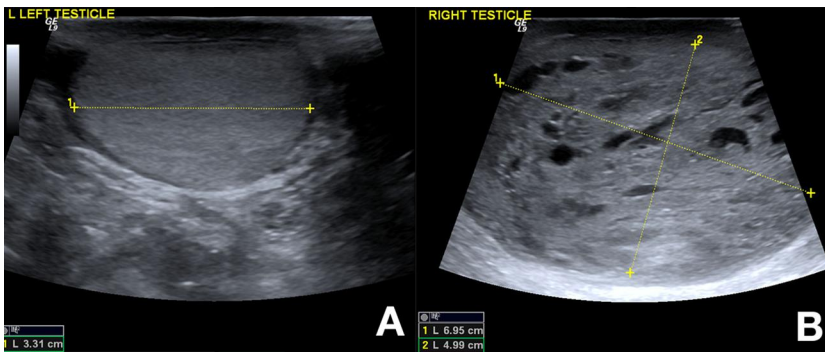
Testicular ultrasound scan of patient with normal left testis (A) and a germ cell tumour in the right testis (B)
